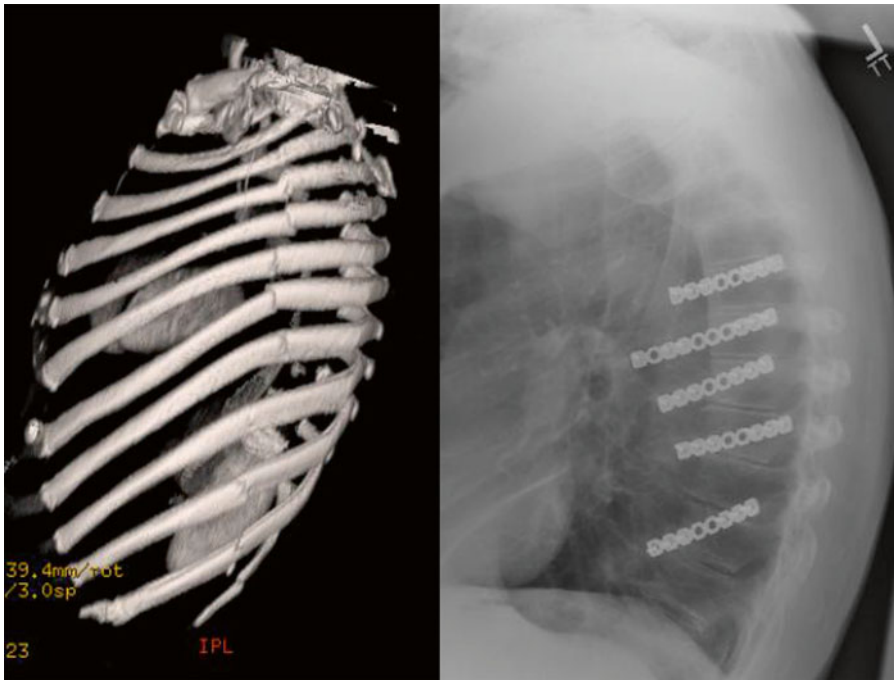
A 3D CT scan revealing multiple ipsilateral displaced rib fractures and a postoperative radiograph following open reduction and plate fixation. This fixation
